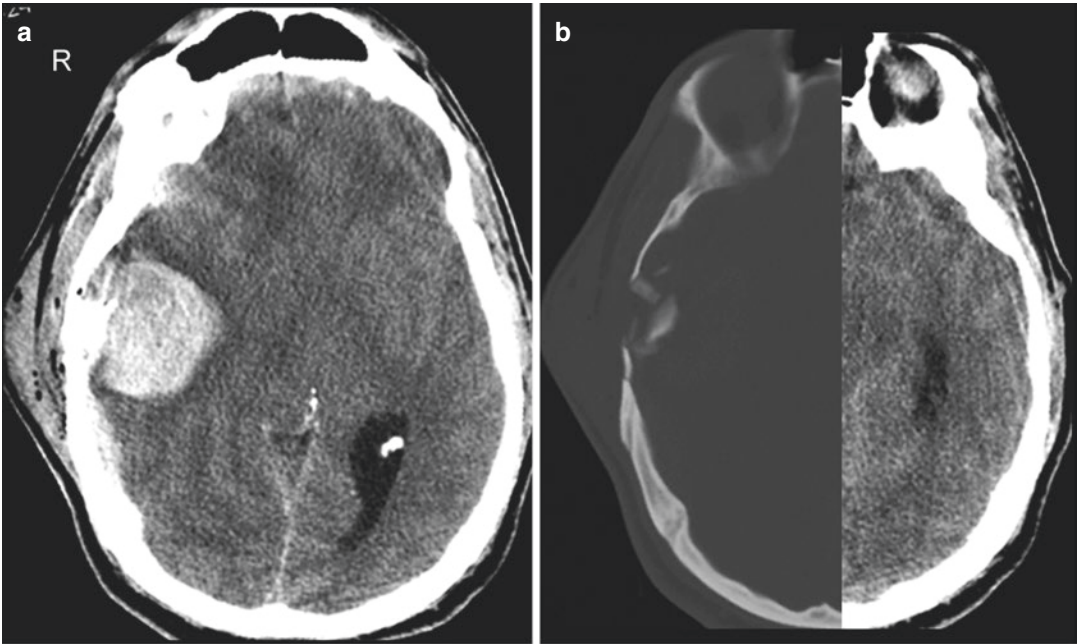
ICH and skull fractures. (a) Non-contrast axial CT image from a patient who sustained a snowboarding accident shows a large, round, right posterior frontal intracerebral high attenuation mass due to an acute intracerebral
